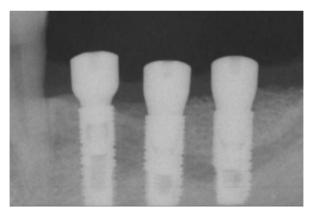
Radiograph taken immediately after placing implants in the graft site.
